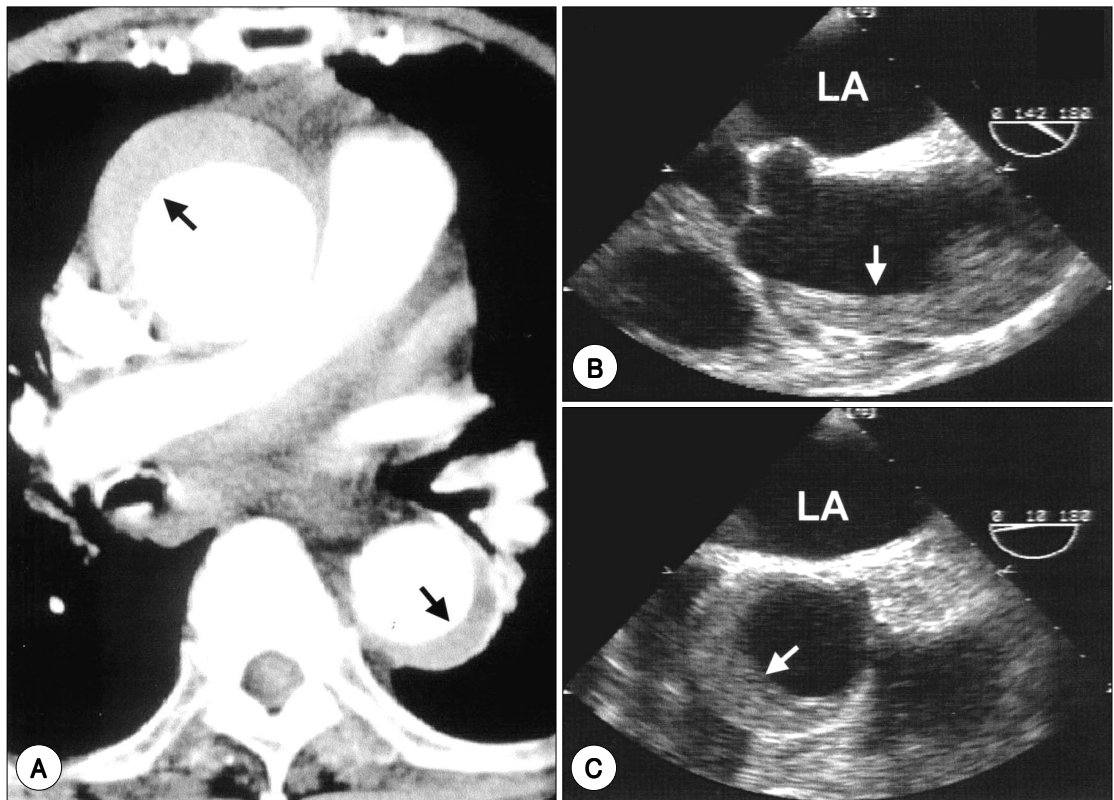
Representative CT (A) and TEE (B and C) findings of typical aortic intramural hematoma ; intimal tear or flap is absent and crescentic thickening of aortic wall without contrast enhancement or flow communication is characteristic. LA : left atrium.
